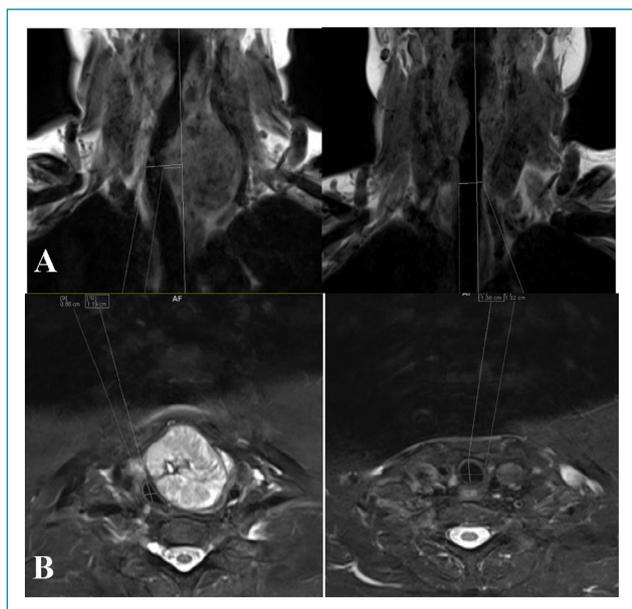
(A) Magnetic resonance image of the change in pre- and postoperative tracheal deviations. (B) Magnetic resonance image of the change in pre- and postoperative tracheal lateral and anteroposterior diameters.
